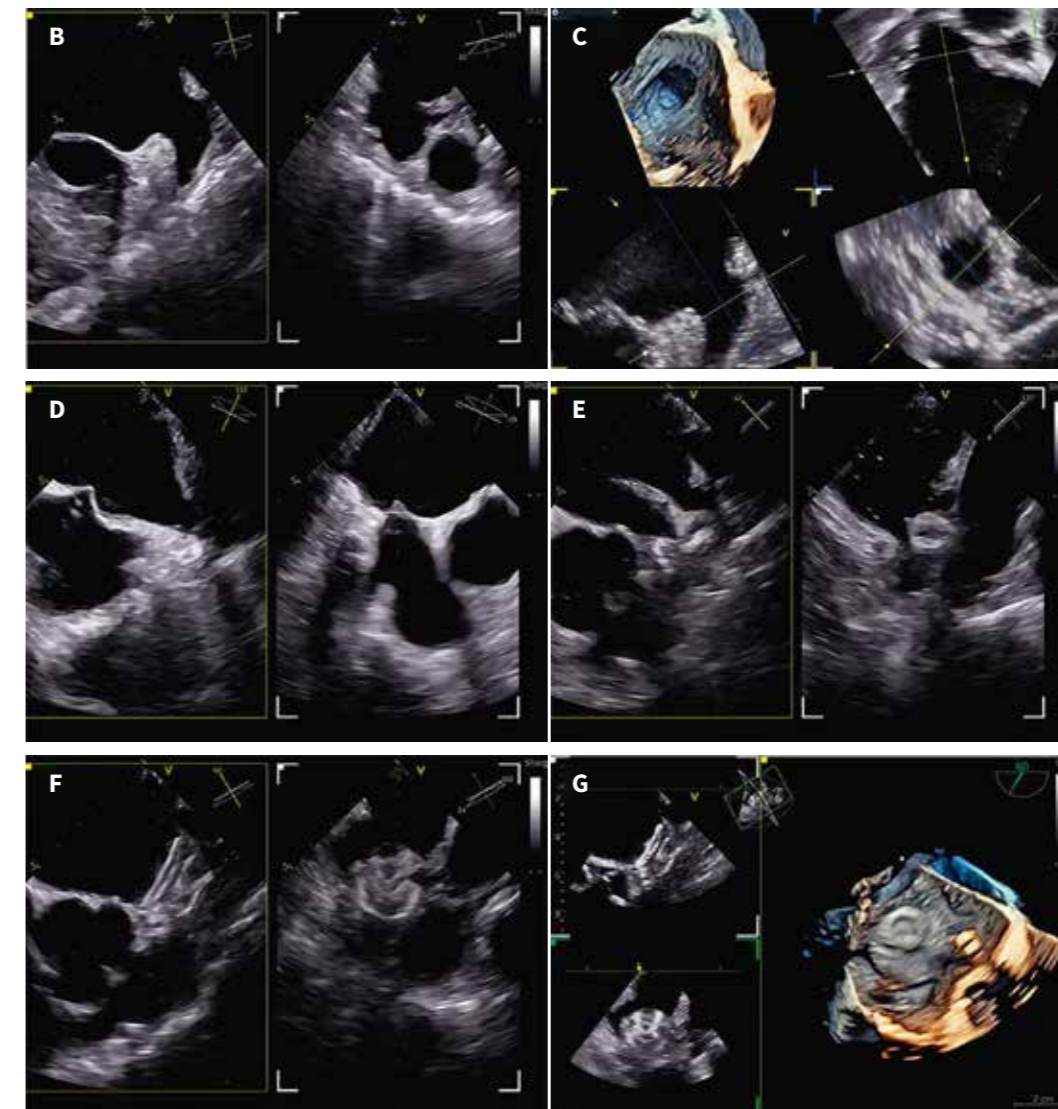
Interventional echocardiographic images during left atrial appendage occlusion of the first patient. A) A comparison of the mini 4D probe 9VT-D (centre, green circle) with the standard 4D probe 6VT-D (top) and the micro 2D probe 10T-D (bottom). TOE images of patient #1 during LAAO: B) LAA with bi-plane view, C) 3D LAA image with multiplanar reconstruction for landing zone measurement, D) bi-plane view for transseptal puncture with the needle inducing tenting in the septum, E) initial positioning of the device with bi-plane view, F) final position of the device with bi-plane and 3D imaging (G). 3D: three-dimensional; LAAO: left atrial appendage occlusion; TOE: transoesophageal echocardiography
